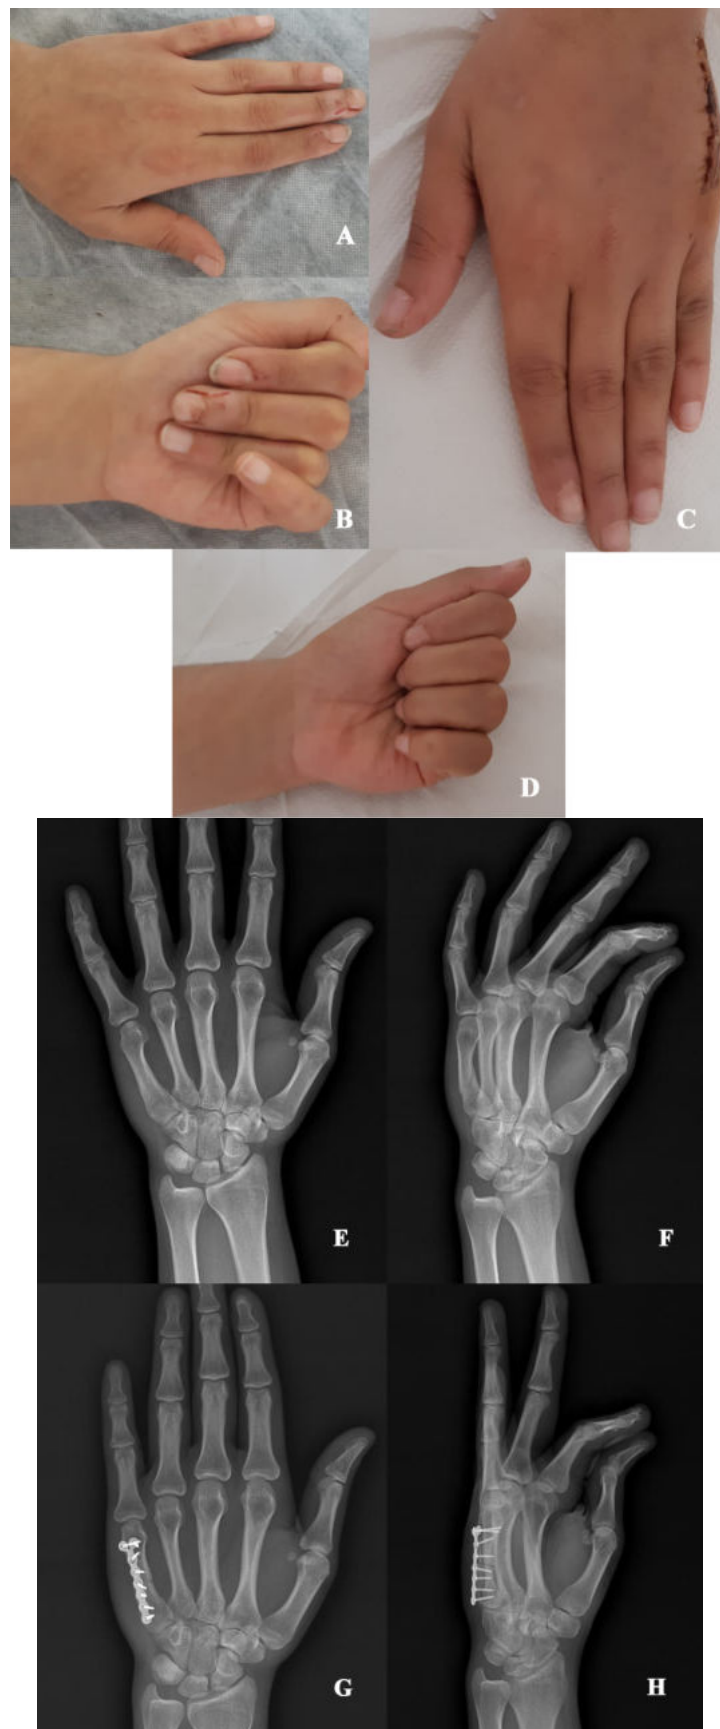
A-B: Malrotation of the small finger caused scissoring during finger flexion, C-D: postoperative 2. week clinical images after the rotational deformity was corrected, E-F: preoperative and, G-H: postoperative 6. week radiographs of the same patient.
